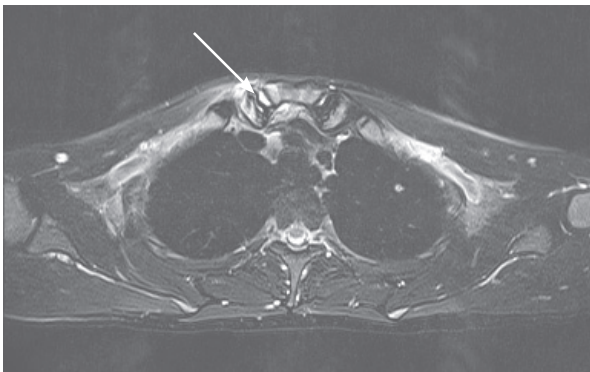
MRI of the SCJ in a 25-year-old man, demonstrating joint space widening and intra-articular effusion
